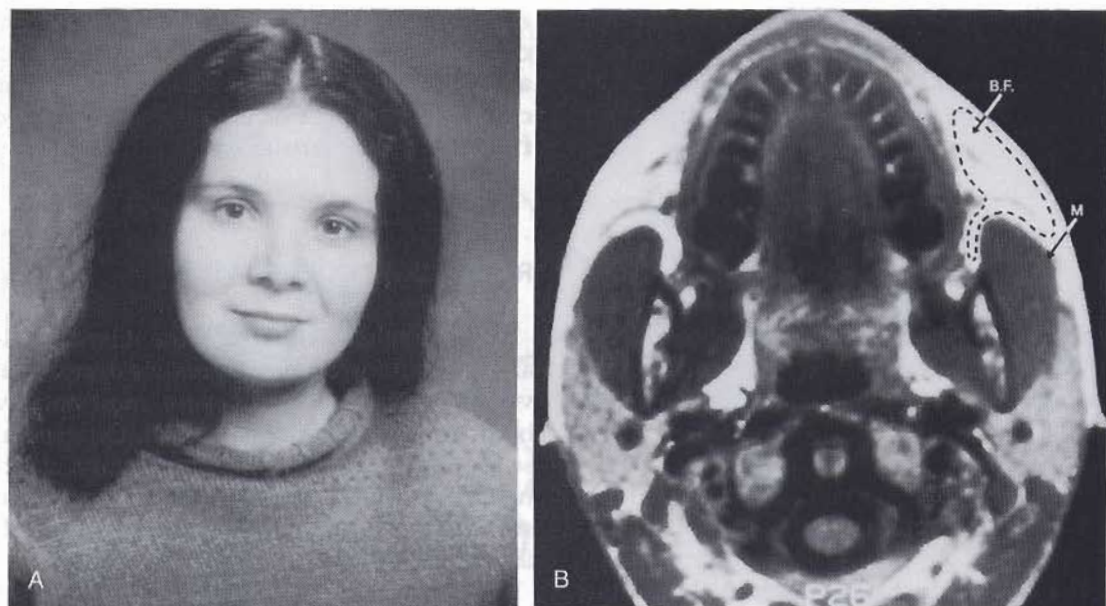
A, Case 1. Photograph of normal appearing, 135-pound, 30-year-old woman. B, MR image of patient in A. Dotted line shows location of buccal fat pad (BF). Note location of masseter muscle (M).
